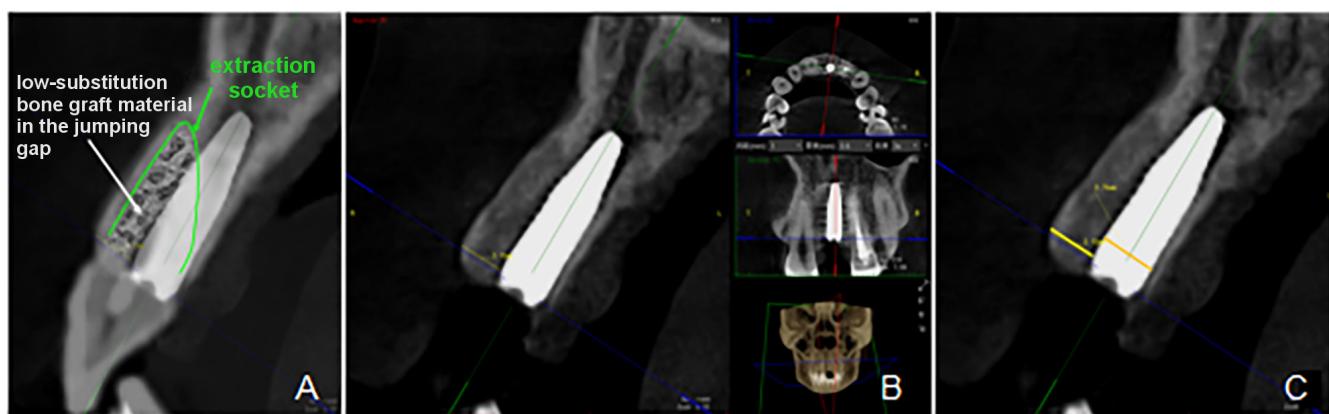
Cone-beam computed tomography (CBCT) measurement of the implant diameter and the labial alveolar bone thickness
